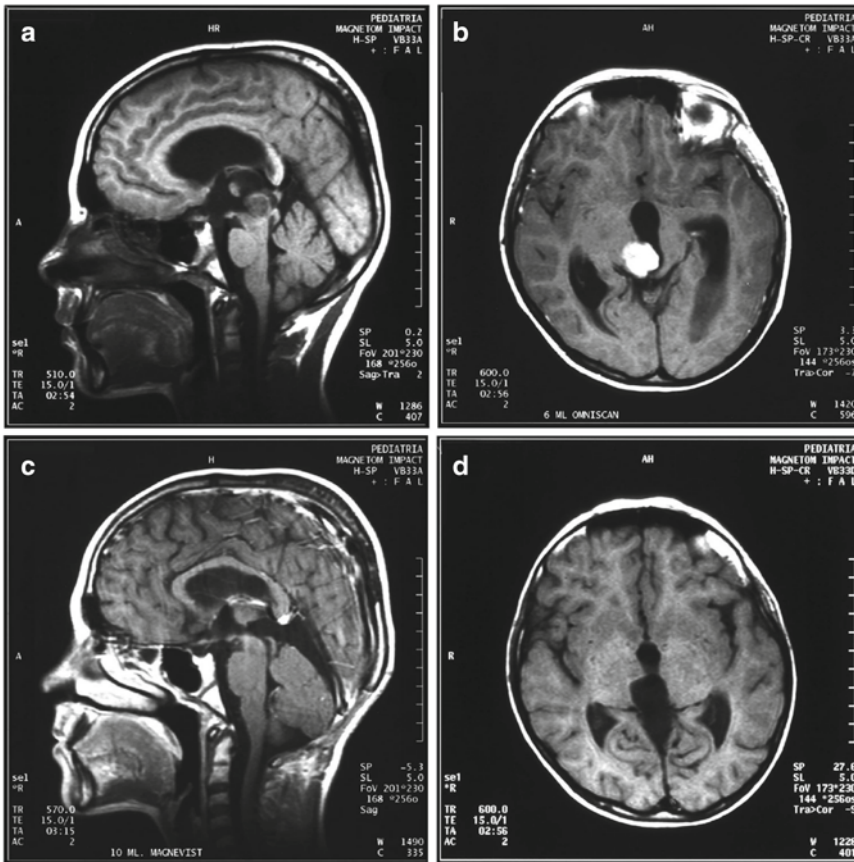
Magnetic resonance imaging of pineocytoma. (a) and (c) Sagittal T1-weighted MRI without gadolinium; (b) and (d) axial T1-weighted MRI with gadolinium.
